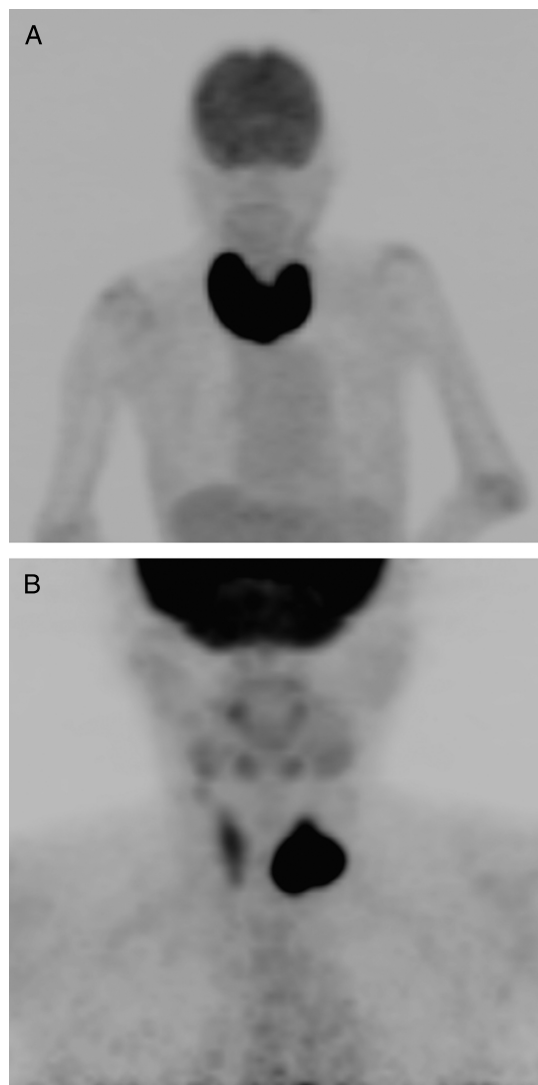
^{18}F -FDG uptake pattern of the thyroid gland. Shown are examples of maximum-intensity-projection images with diffuse uptake (A) and diffuse plus focal uptake (B).
